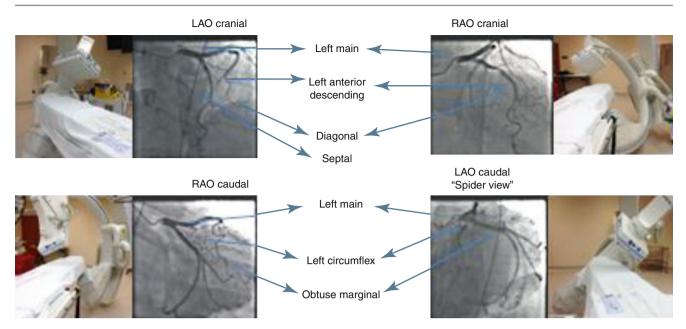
Angiographic views of the left coronary artery. The approximate positions of the x-ray tube and image intensifier are shown for each of the commonly used angiographic views
